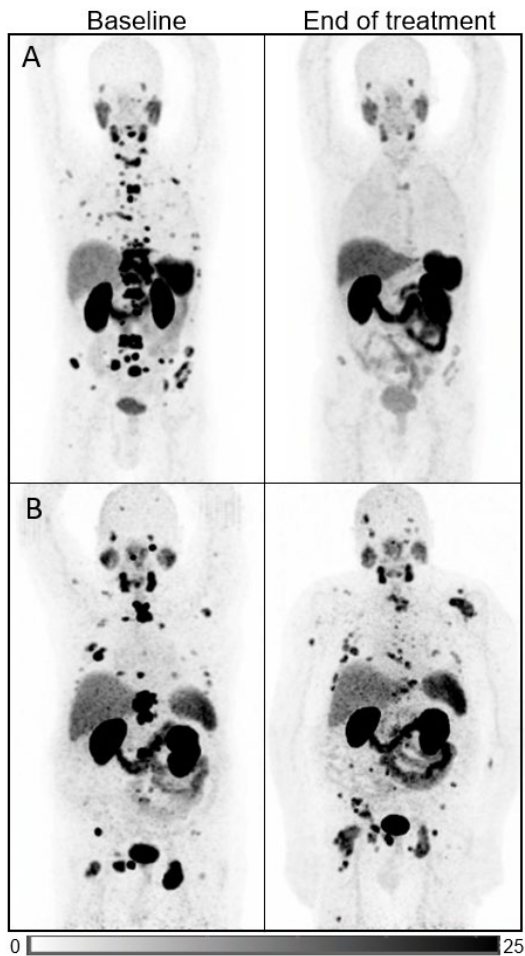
Patient A is a ‘responder’, showing a homogeneous reduction in PSMA intensity. Patient B is a ‘progressor’, with persistently high and heterogeneous PSMA expression.
